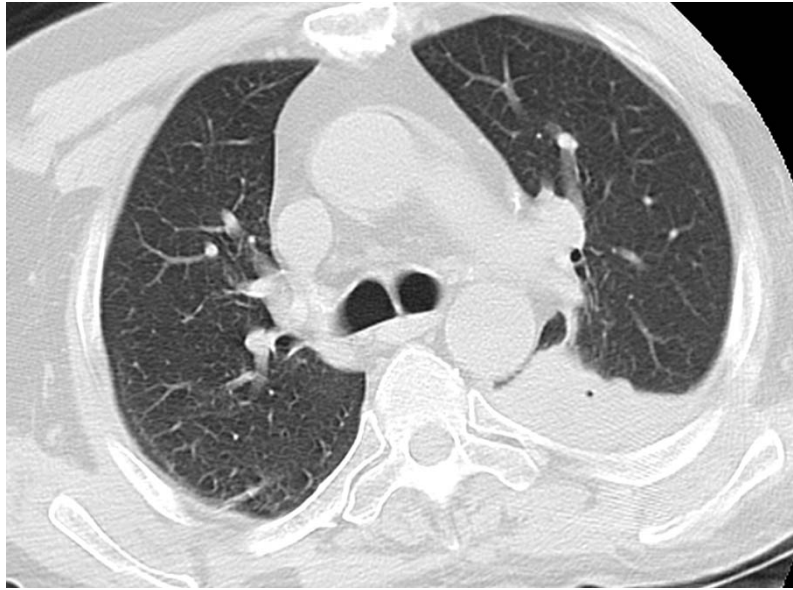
Chest CT showing pulmonary consolidation in the left posterior-inferior lobe
